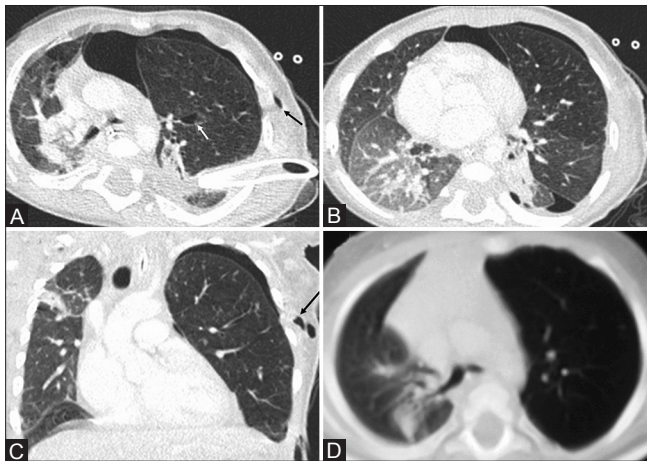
(A-D): A 7-month-old child with multiple chest tube insertions due to clinical suspicion of pneumothorax. Chest CT images lung window axial and coronal views (A-C) show a slightly hyperinflated left upper lobe with a pneumothorax due to multiple chest tube insertions (black and white arrows). However, on comparison with adjacent lung segments, the hyperinflation is not obvious for definitive diagnosis of CLE. (D) Follow-up CT 3 months later shows hyperinflated left upper lobe with attenuated vascular markings, diagnostic for CLE. Diagnosis was confirmed after surgery
